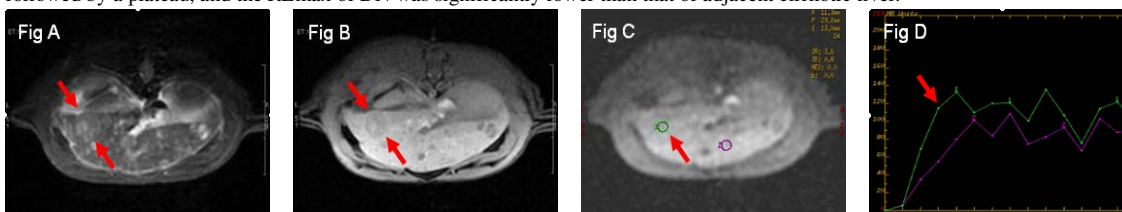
Well-differentiated HCC. The lesion (red arrow) showed heterogeneous hyperintense on fat saturated T2WI (Fig A) and heterogeneous hypointense on T1WI (Fig B), DCE-MR images of the HCC and adjacent cirrhotic liver (Fig C) and RE-T curves of the HCC and adjacent cirrhotic liver (Fig D). The curve of HCC (green line) shows a pattern like rapid wash-in and rapid wash-out, which indicates that HCC presents increased blood supply and were predominantly supplied by hepatic arteries.
